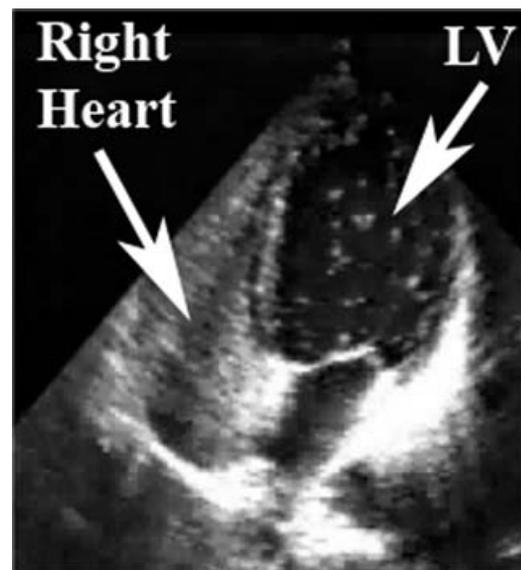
TTE apical four-chamber view during injection of agitated saline via the right antecubital vein. Injection and imaging were performed during normal respiration. The right atrium and right ventricle (right heart) are completely opacified. Saline contrast appeared within the left atrium and left ventricle (LV) only a brief moment after opacifying the right heart. Since contrast appeared within the left heart during normal respirations, the patient had evidence of a “resting shunt.”
